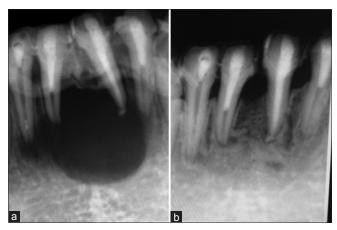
Case 3 14/F: (a) Intraoral radiograph showing a large cystic lesion involving all mandibular incisors; the roots of teeth #41 and 31 are pushed apart. (b) At 8-month follow-up after surgical fenestration, SealBio, and splinting for 3 weeks, excellent healing response is seen
